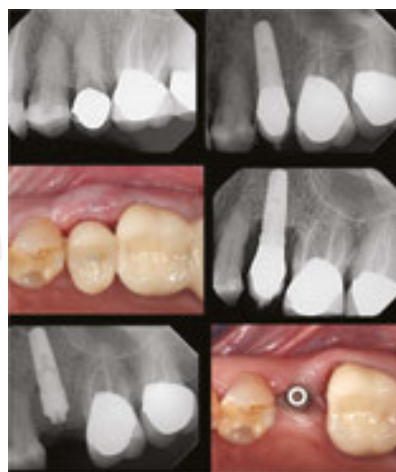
Top: Deep decay was under the margin of the crown on the second premolar, so the tooth was replaced with an immediately loaded provisional restoration. Center: Six weeks later, she returned with pain and gross inflammation of the marginal gingiva. A radiograph showed rapid breakdown around the collar of the implant. It was removed, and the region debrided. A fresh implant was placed with a bottleneck gingivaformer and closed after further augmentation. Bottom: Four weeks later, the inflammation in the soft tissue complex is resolving well and further healing can be expected.
